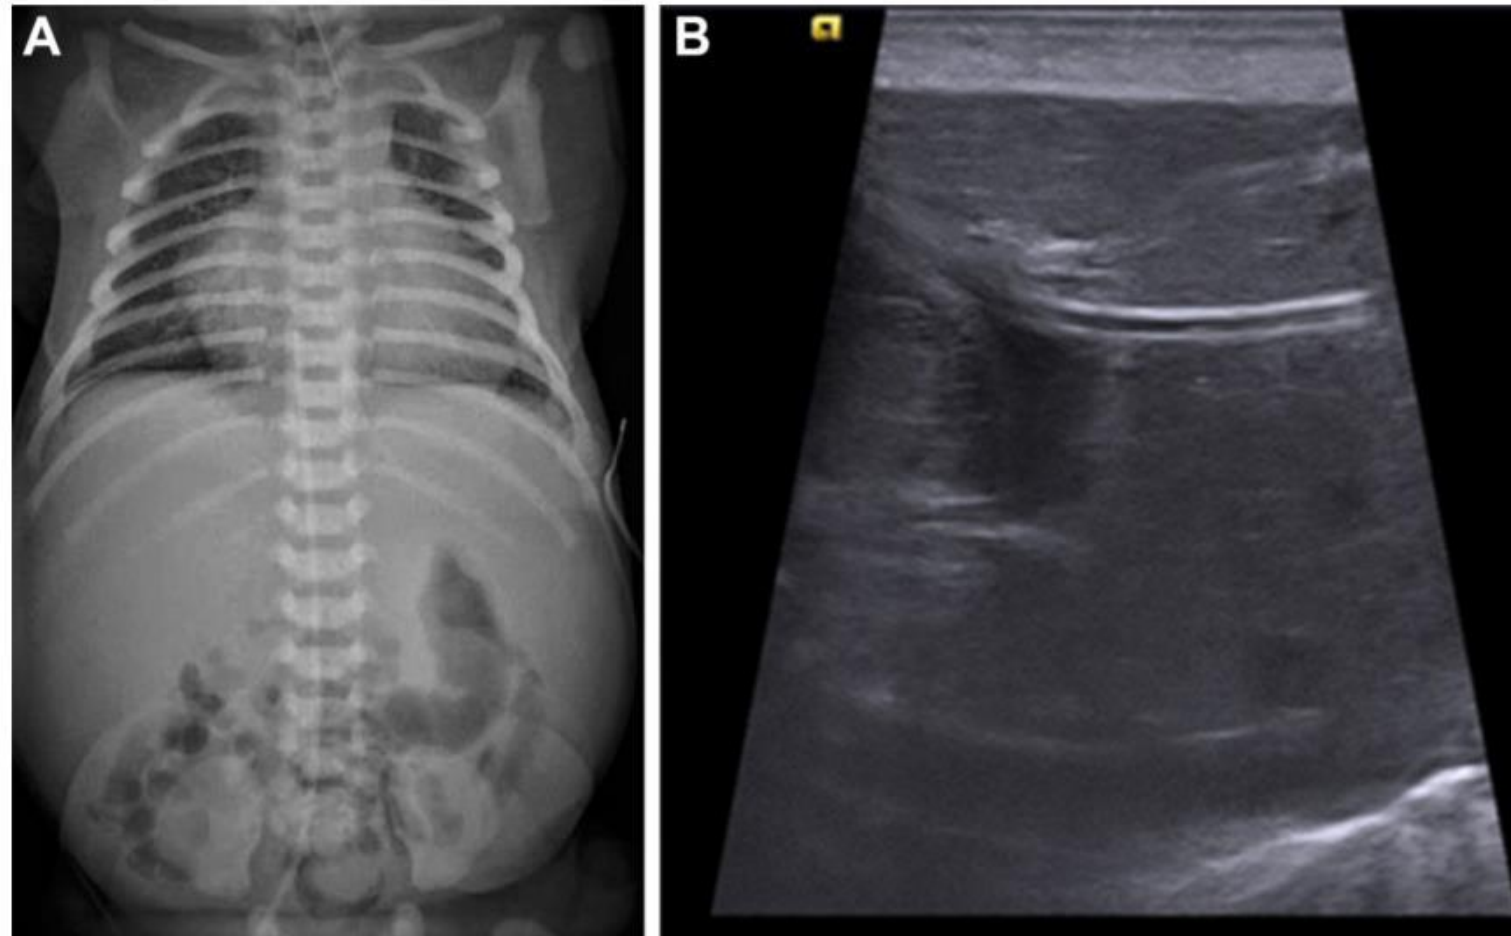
On X-ray the umbilical venous catheter (UVC) lies at T9 but the line curves away from the heart and the tip does not point towards the right atrium (A). On a sagittal ultrasound scan the UVC in this baby has crossed the anterior portal sinus entering a vessel arising from it (B).
